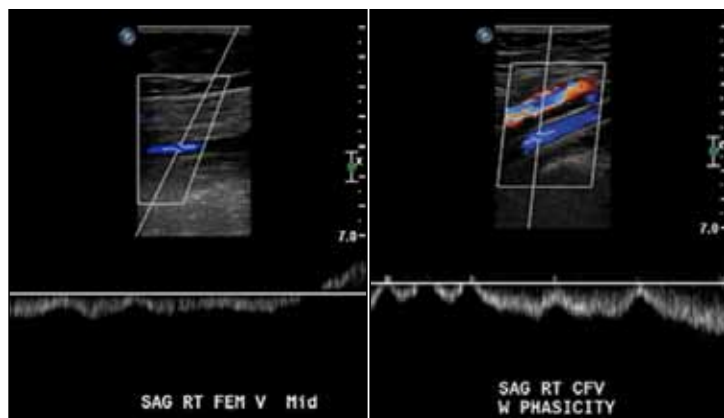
Eighteen-month follow-up color Doppler shows wall-to-wall patency throughout the right lower extremity.
